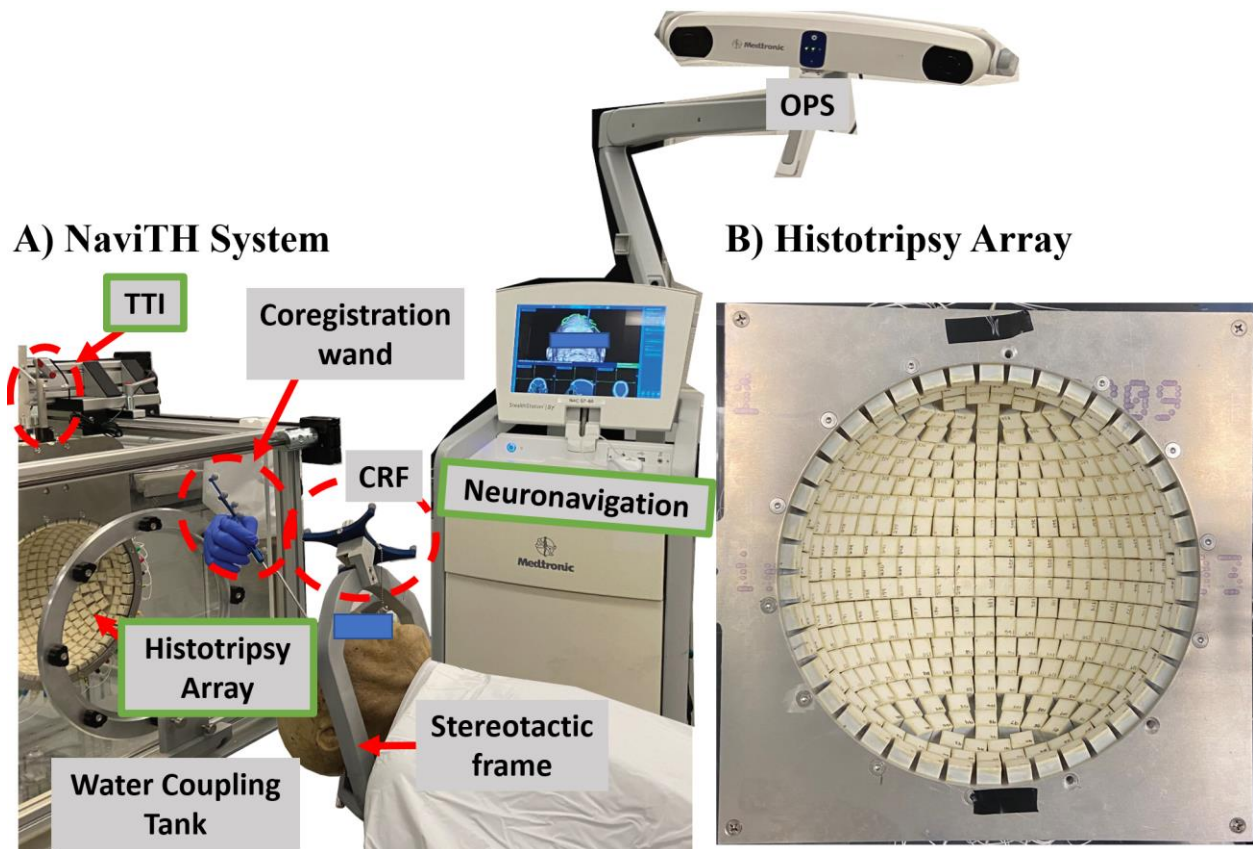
Neuronavigation-guided Transcranial Histotripsy (NaviTH) system. The NaviTH system (A) mainly consists of a neuronavigation system, a histotripsy array, and a transducer tracking instrument (TTI) fixed to the histotripsy array. The neuronavigation system has an optical positioning system (OPS) for the optical tracking of instruments such as the coordinate reference frame (CRF), a co-registration wand, and the TTI. The CRF is fixed to the stereotactic frame attached to the patient's head, the co-registration wand is used to map the patient CT/MRI to the CRF, and the TTI maps the focus of the histotripsy array. The water coupling tank contains the histotripsy array and TTI to ensure ultrasound transmission from the histotripsy array (B) to the patient's head.
